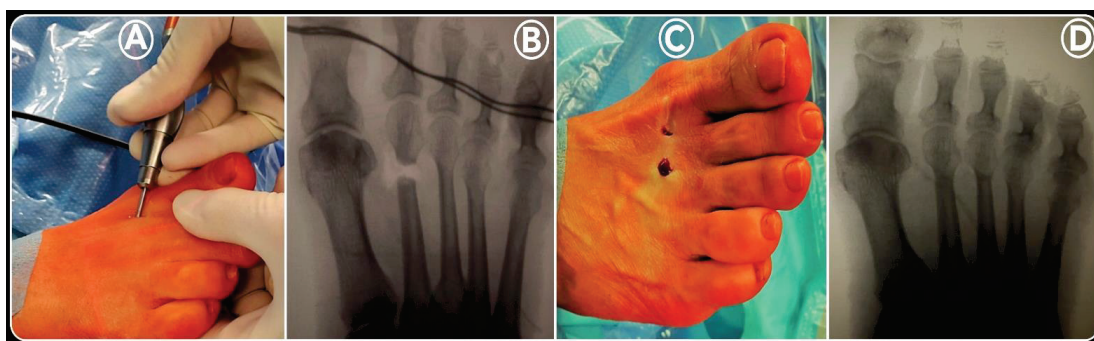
DMMO intraoperative images (2nd)*: in this position, the DMMO was performed with an angle of approximately 45° with respect to the long axis of the MB in a dorsal-distal to proximal-plantar direction, with rotary motion, extending to the contralateral cortex (A). To verify the completion of the osteotomy of each MB operated on, manual traction on the corresponding toe was applied under fluoroscopic control (B). Before closing the wounds by resorbable sutures (C), the MBs were manually compacted, applying pressure in the distal-proximal direction, pushing their heads dorsally. Finally, after bandage application, a final radiographic check was made to evaluate the correction obtained (D).
